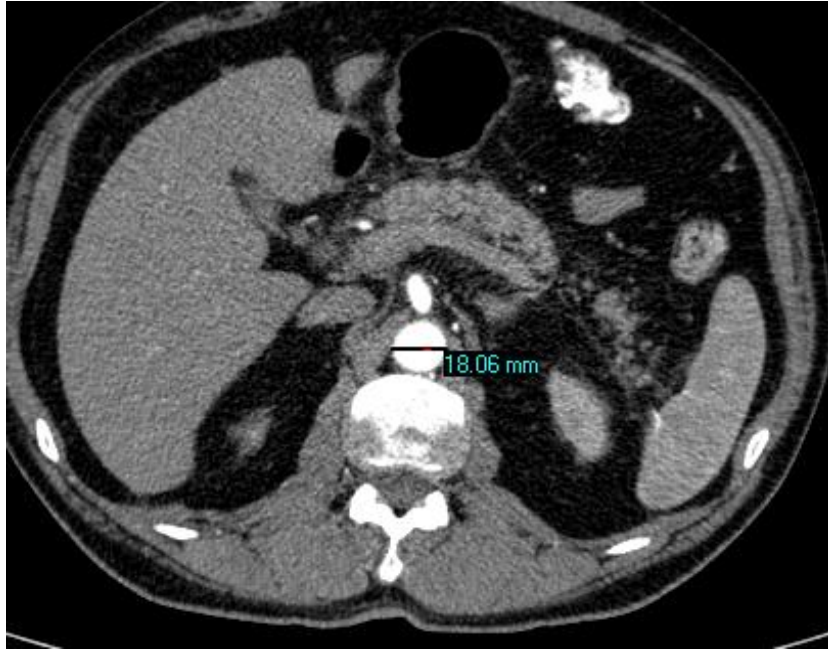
Axial CT Scan image showing aortic diameters measurements of 71 years old male at L 3 level
